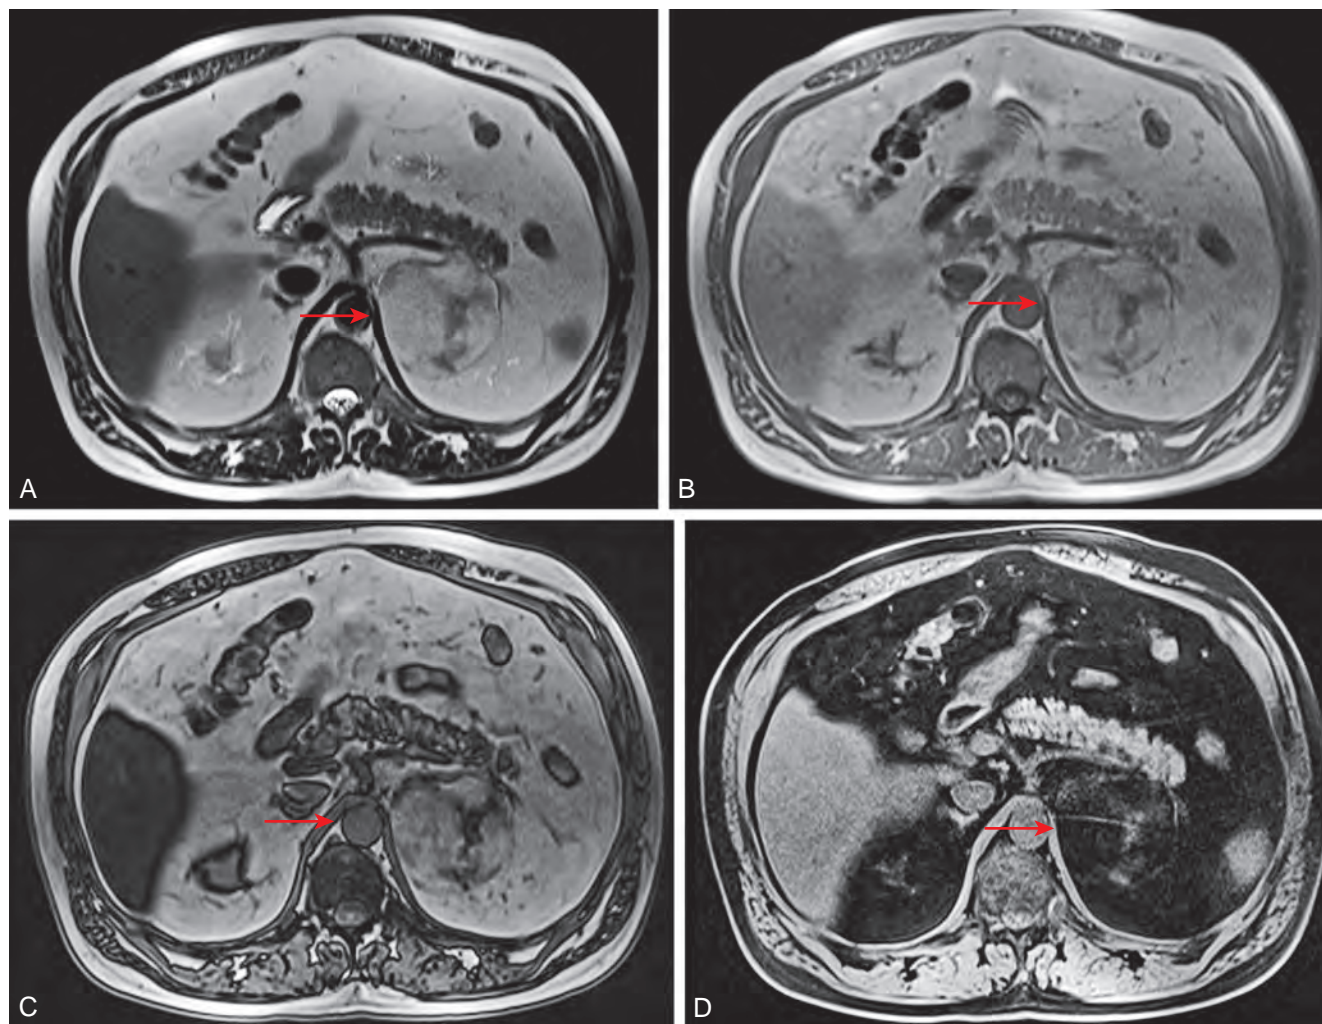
A 44-year-old man, with prior abdominal ultrasonography detecting an indeterminate renal mass, underwent 1.5-tesla magnetic resonance imaging with chemical shift imaging, which was consistent with left adrenal myelolipoma (red arrow). A, T2 single-shot spin echo demonstrates a large left adrenal mass with signal isointense to abdominal fat. B, T1 in-phase imaging demonstrates a left adrenal mass with signal similar to the abdominal fat. C, T1 out-of-phase imaging shows no drop of signal compared with in-phase imaging. D, T1 fat-suppressed precontrast imaging shows loss of signal within the mass consistent with gross fat.
